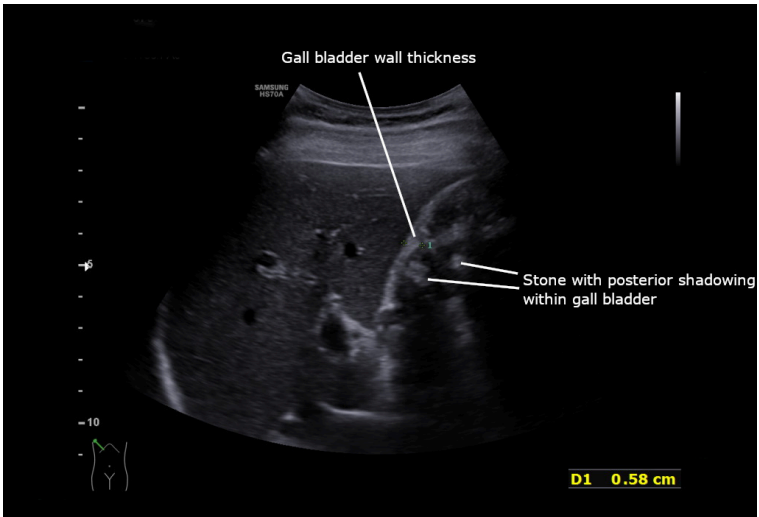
Acute cholecystitis as seen on the ultrasound axial view. [Acute cholecystitis as seen on ultrasound axial view](#) by Cerebisae licensed under [CC BY-SA 4.0](#)
